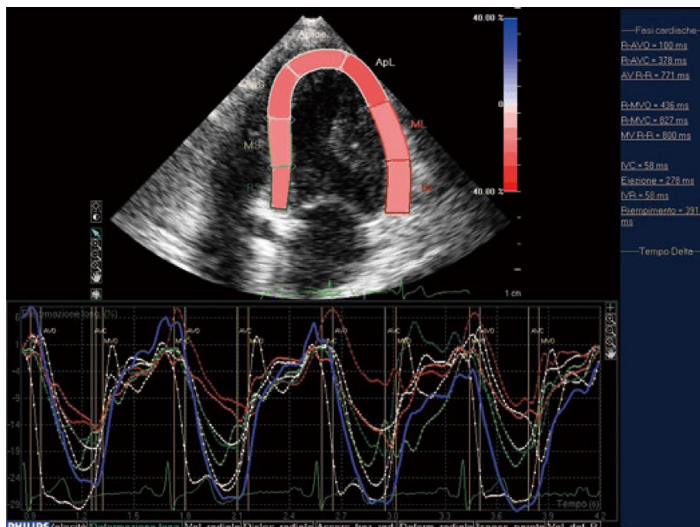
Systolic myocardial deformation after electromechanical activation. Left ventricular longitudinal strain from the apical four-chamber view: time strain curves show a negative end-systolic strain representing myocardial shortening during systole.
